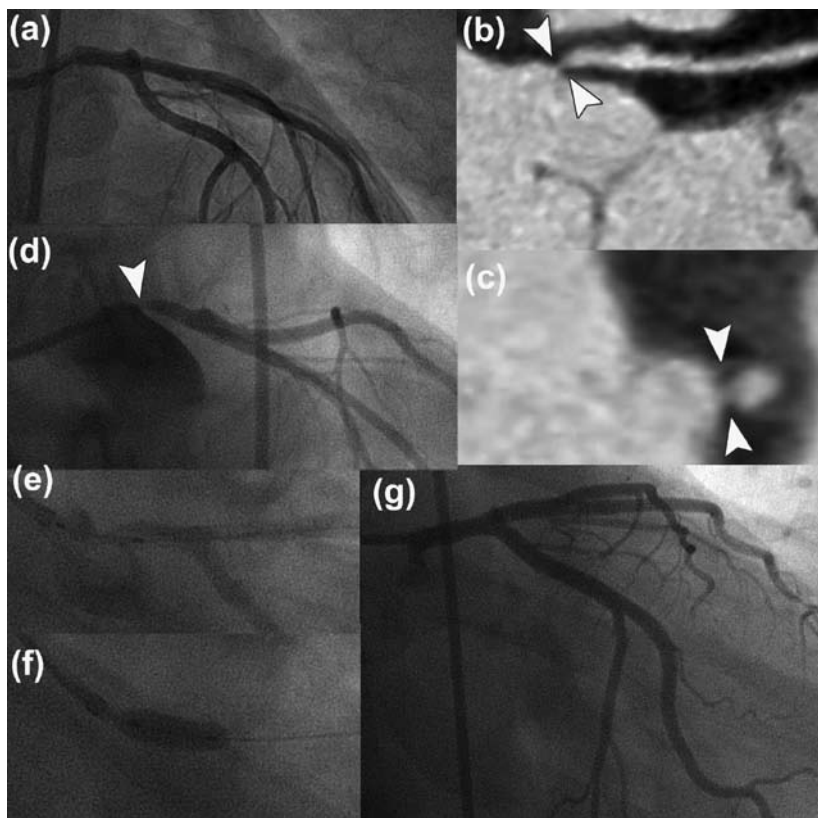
(a) Diagnostic coronary angiogram of the left coronary artery in a female patient with atypical chest pain who presented with ventricular fibrillation during a bicycle stress test. Although not visible there was a suspicion of ostial left main disease because of the absence of contrast back flow in the coronary sinus. (b and c) The CT coronary angiogram clearly shows a severe ostial narrowing (arrowheads). (d) A non-selective repeated invasive coronary angiogram confirms the CT findings (arrowhead). (e and f) A percutaneous coronary intervention was performed: shown are the positioning and deployment of the stent. (g) Postprocedural coronary angiogram.
